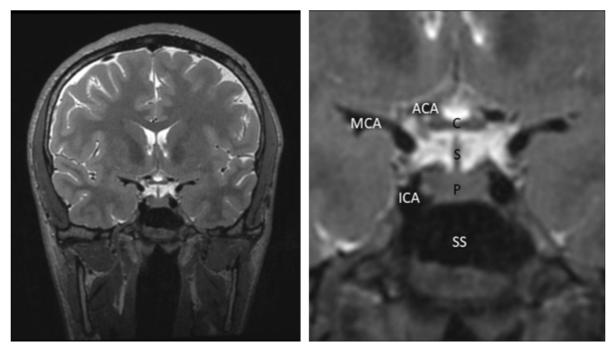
Coronal T2-weighted image demonstrates normal sellar and parasellar anatomy and delineates the local anatomical boundaries of the pituitary fossa. The pituitary gland (P) is sited within the sella turcica, with the sphenoid sinus (SS) demonstrated inferiorly. The pituitary stalk (S) is seen extending vertically through the suprasellar space in the midline. Superior to this is the optic chiasm (C). The lateral borders of the pituitary fossa are formed by the cavernous sinuses. On this coronal image, the T2 flow voids through the cavernous segments of the ICAs occupy the cavernous sinuses.
